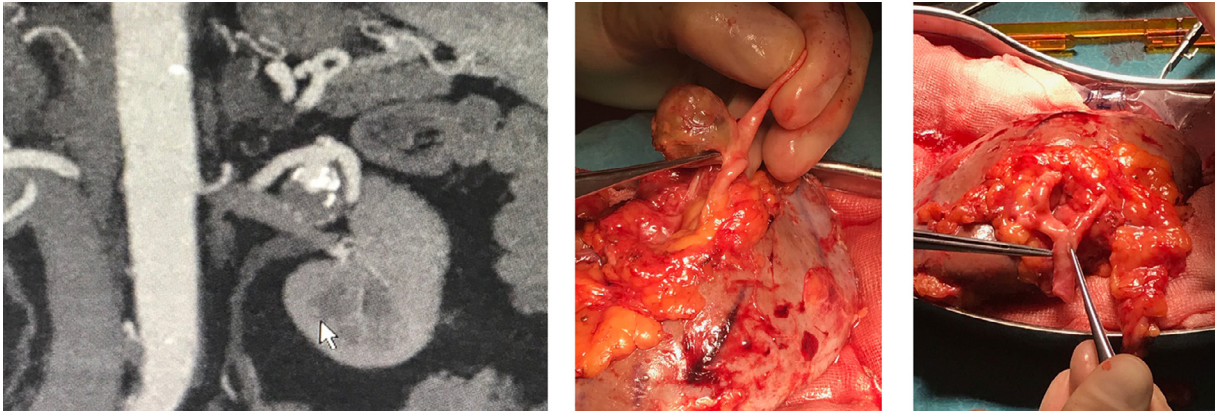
A case of 68 year-old male with renal artery aneurysm (Case 8). (A) Computed tomography image shows a 3 cm saccular renal artery aneurysm partly thrombosed at the first bifurcation of the left kidney. (B) After laparoscopic nephrectomy of the left kidney, renal artery aneurysm was identified and prepared for ex-vivo renal artery reconstruction on the bench table. (C) After resecting the aneurysm, an end-to-end anastomosis was performed.
